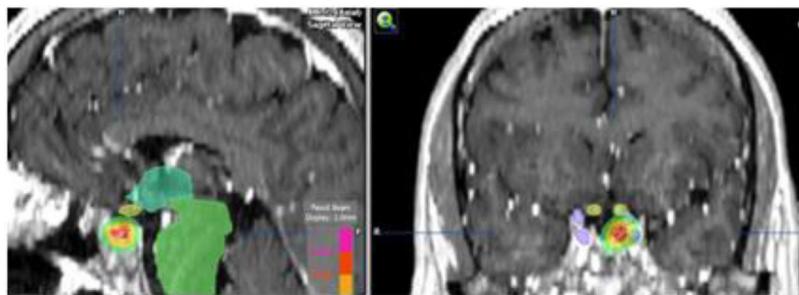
Dosimetry (MRI T1 post-gadolinium weighted coronal and sagittal images) of re-irradiation with radiosurgery (Novalis[®]), dose 12 Gy, in a patient with an uncontrollable acromegaly with medical therapy. He had received fractionated stereotactic radiotherapy (54 Gy) 12 years before.
